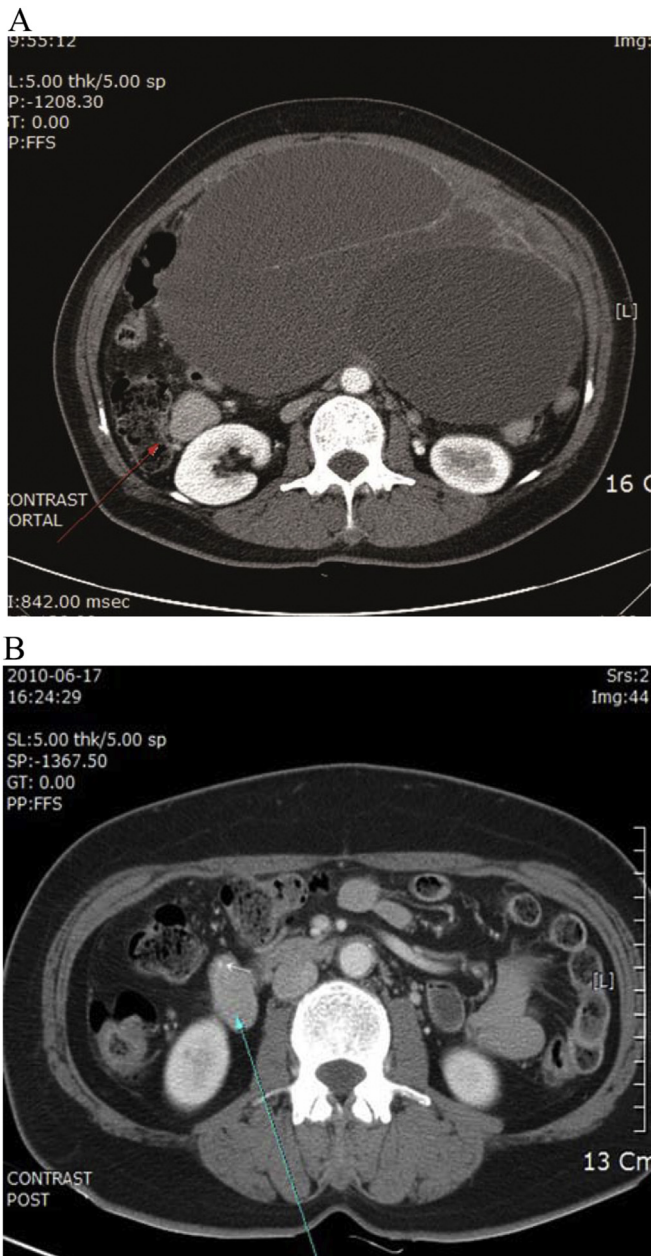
CT scans reveals a well-enhanced 3-cm mass in the anterior lower pole of the right kidney. This nodule was a homogenous solid mass with eccentric calcifications. (A) Pre-operative CT before total abdominal hysterectomy and bilateral salpingo-oophorectomy at another university hospital. (B) Axial contrast-enhanced CT shows a homogeneous retroperitoneal soft-tissue mass (blue arrow) displacing the pancreaticoduodenal vessel (white arrow) anteriorly. CT = computed tomography.
